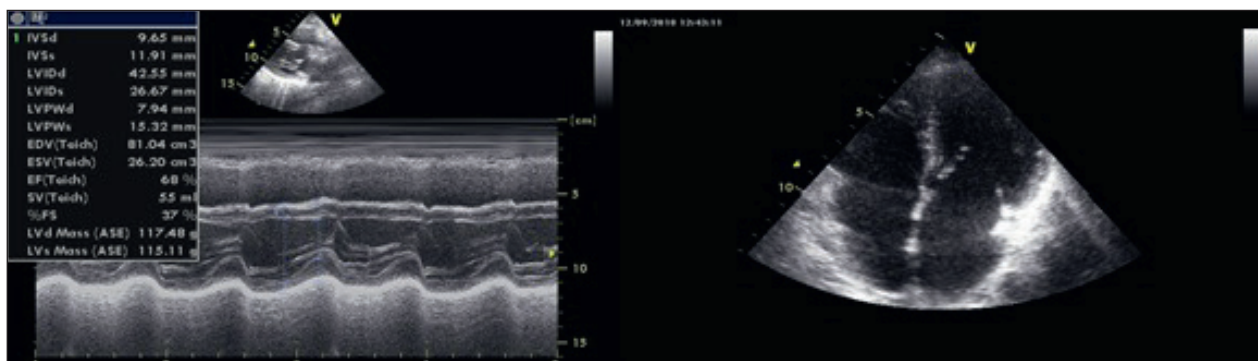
Echocardiographic findings 3-month after heart transplantation. The apical view and M-mode scan of the left ventricle derived from two-dimensional parasternal long axis view show a normal ventricular cavity diameters and ventricular systolic function.
